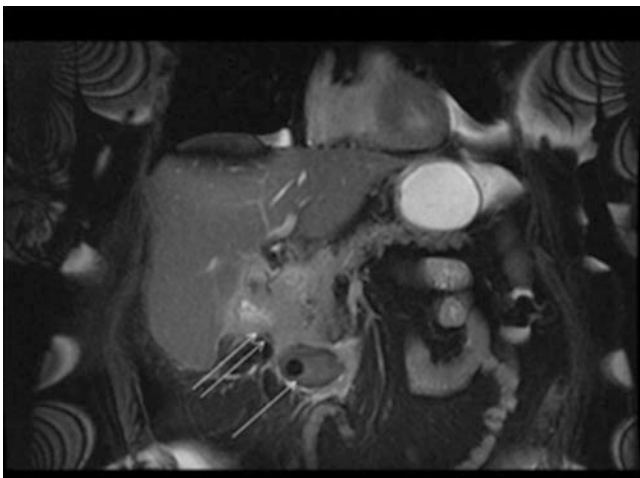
Demonstrated is an MRI of a patient with an impacted duodenal gallstone (*single arrow*) leading to gastric outlet obstruction (Bouveret's syndrome) secondary to cholecystoduodenal fistula (*double arrow*). (From Shah, S.K., et al., *Bouveret syndrome*. J Gastrointest Surg, 2013. 17(9): p. 1720–1, with permission.)
